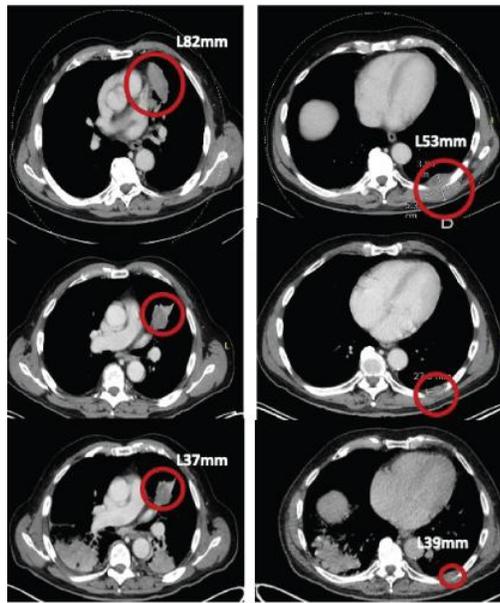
CT scan and PET-CT for Patient D01_B at enrollment (top) and following EVX-01 treatment (bottom).
